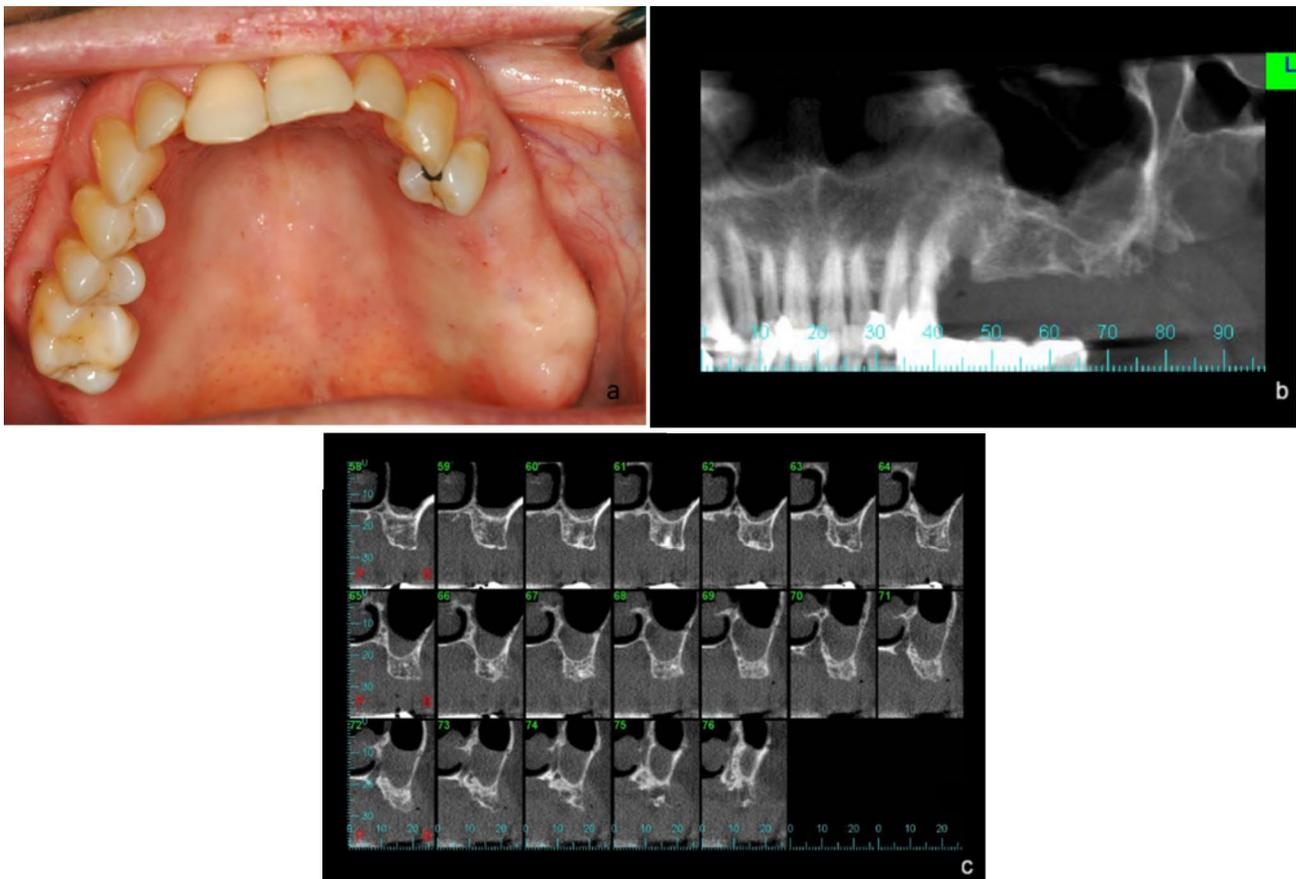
Posterior maxilla rehabilitation through sinus augmentation. a: A preoperative photograph, b: Preoperative panoramic reconstruction from CBCT, and c: Preoperative CBCT paraxial slices highlighting the atrophic alveolar ridge in the maxillary premolars and molars area
